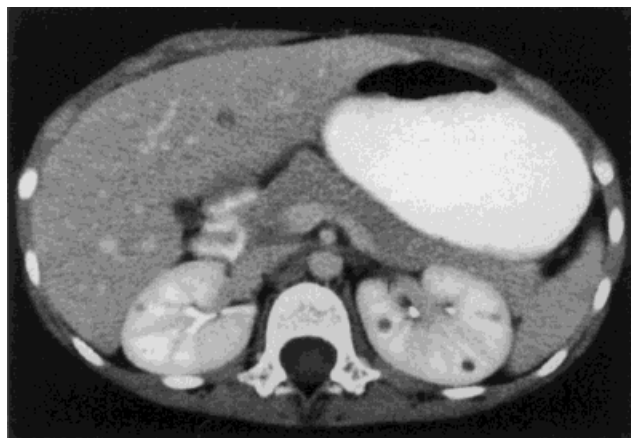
Contrast-enhanced CT scan (patient 1, age 7 years). Axial sections at two different levels of the kidneys demonstrate bilateral renal cysts.
